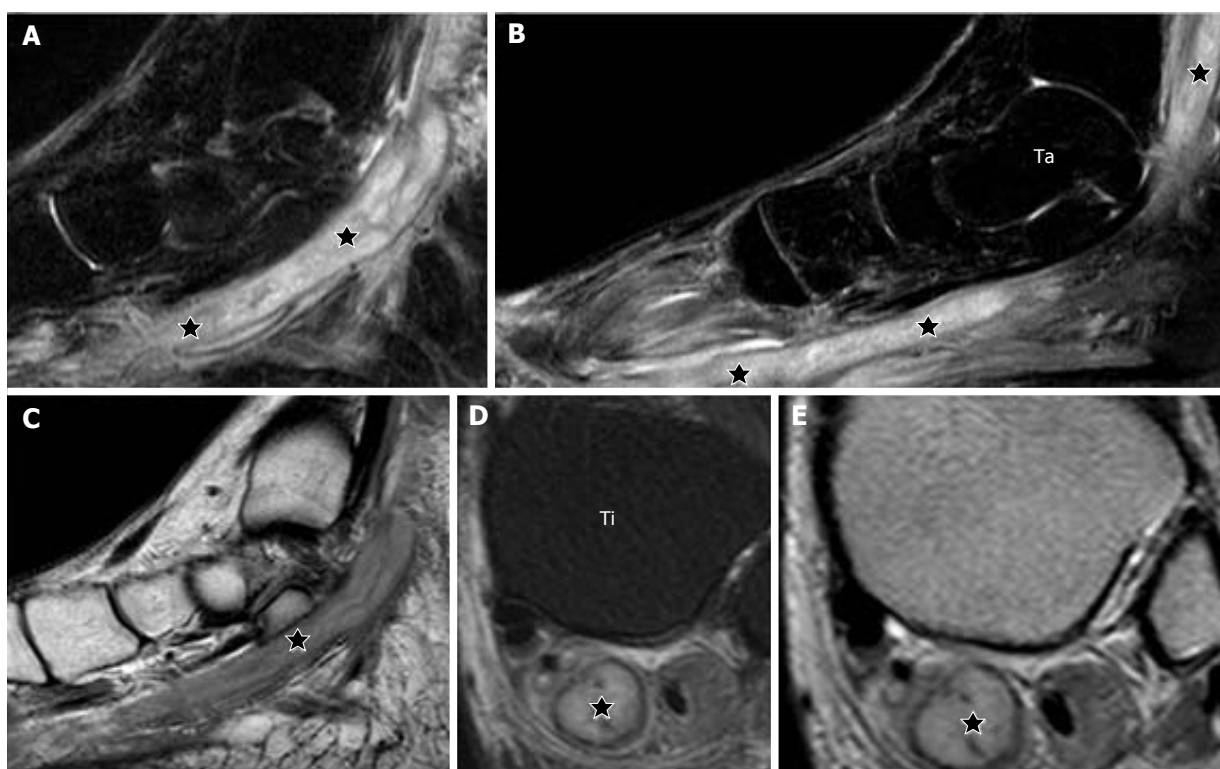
T2-weighted fat suppressed, serial sagittal (A, B); T1-weighted, sagittal (C); T2-weighted fat suppressed, axial (D) and proton density-weighted, axial (E) show an elongated tubular cystic lesion (stars) along the posterior tibial nerve at the lower leg, ankle and foot. The lesion is seen within the substance of the nerve and has a central cystic component (stars) and a peripheral thin wall consistent with an abscess (D, E). This is a case of Hansen's disease with posterior tibial nerve abscess; Ta: Talus; Ti: Tibia.
